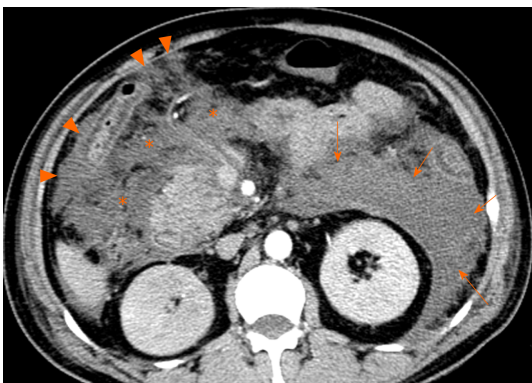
A 53-year-old man with necrotizing pancreatitis. Axial contrast-enhanced computed tomography image in the venous phase shows extensive heterogeneous collections (acute necrotic collections) in the left pararenal anterior spaces (arrows) and the subperitoneal spaces/transverse mesentery areas (asterisks) as well as greater omentum zones (arrowheads).
